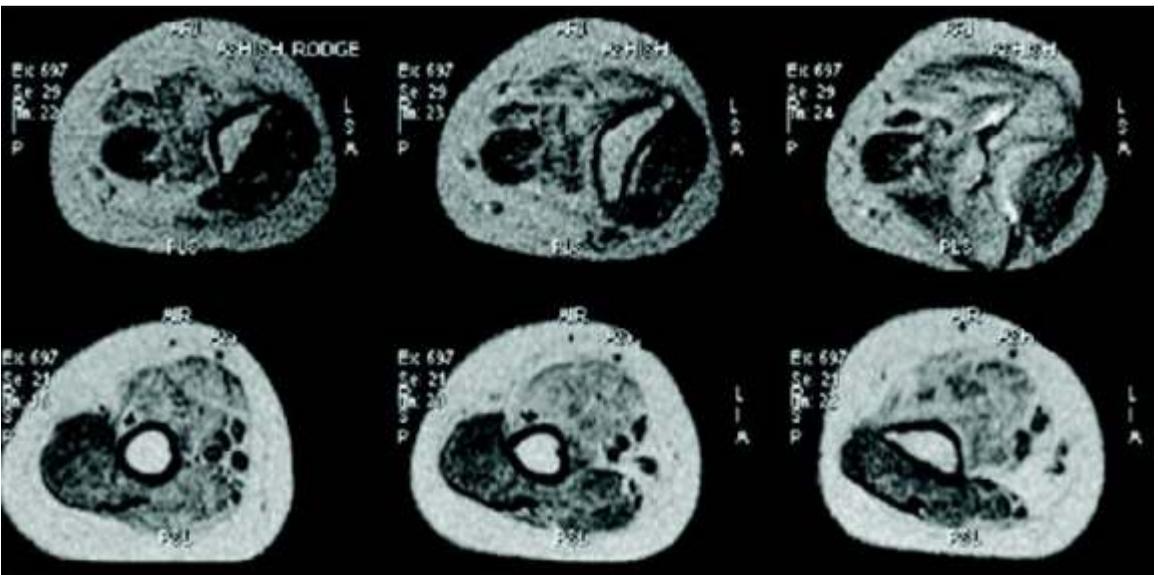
T1 weighted axial musculoskeletal MRI images of Left and Right Long, Medial and Lateral head of Triceps before Autologous BMMNCs transplantation
